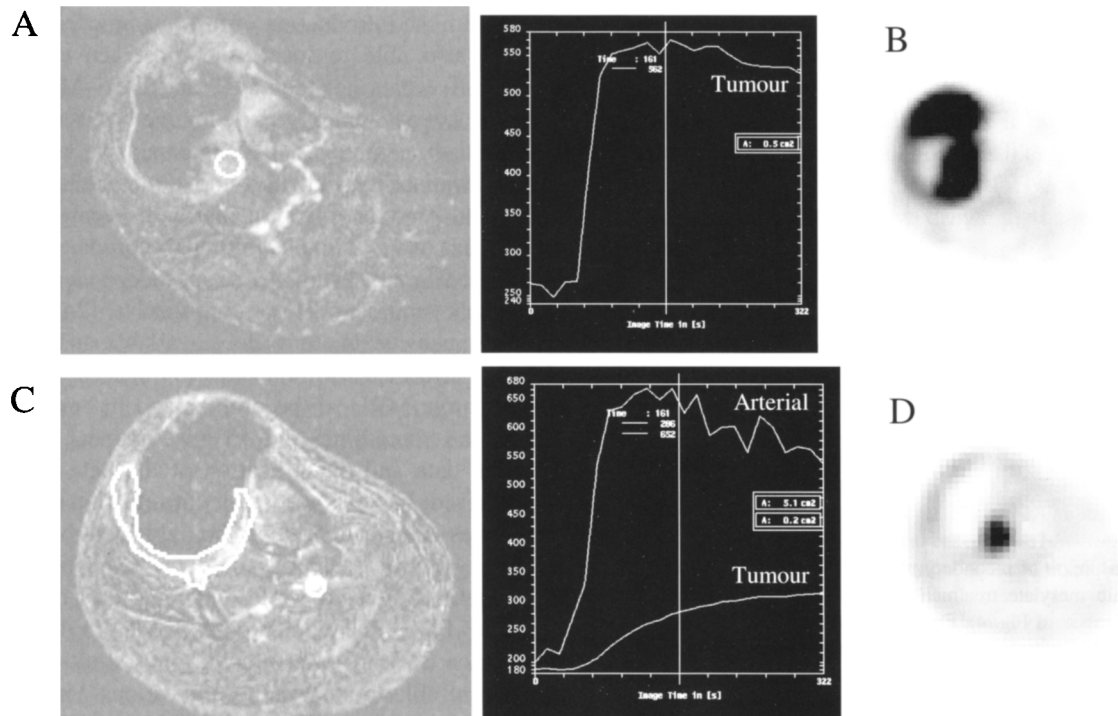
Axial dynamic T1-weighted MRI images of a patient with a high grade leiomyosarcoma in the left thigh before (A) and 4 weeks after limb perfusion (C) with high dose melphalan and tumour necrosis factor. Before chemotherapy, a fast contrast enhancement suggestive for malignancy is observed (A), while after treatment, a major reduction in both the amplitude and the slope is observed (C), suggesting major tumour response. On PET, high FDG uptake was observed in the periphery of the tumour prior to treatment (B). After treatment, a major reduction in FDG uptake was observed throughout the tumour, except for one small focus, suggesting resistant disease at that place (D). The patient was treated with additional radiotherapy (66 Gy), but progressed locally at this PET resistant 3 months later. The failure of MRI to detect this resistant focus can possibly be explained by the use of a too-large ROI (region of interest) for dynamic analysis.
